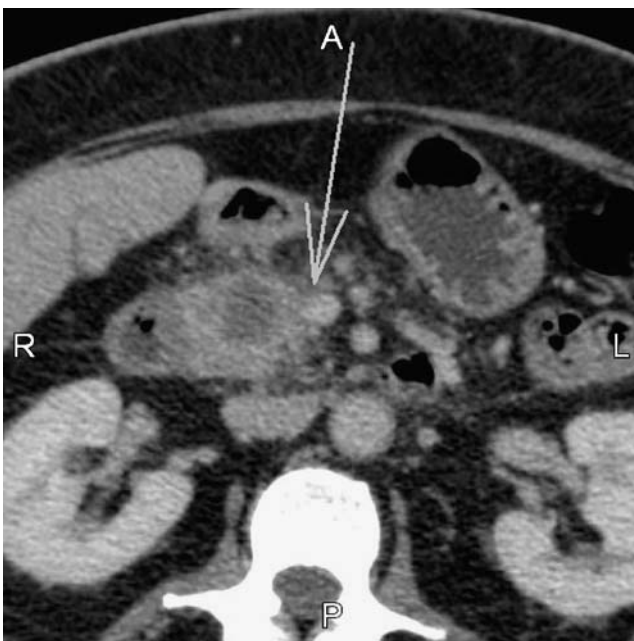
CT scan of the abdomen with a pathologically enlarged lymph node in the celiac region (*arrow*).
